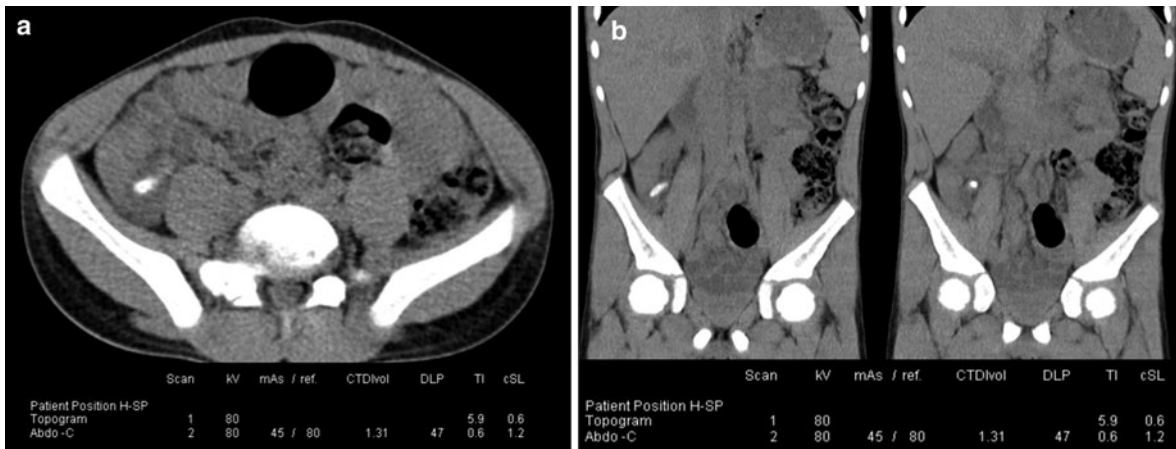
Unenhanced MDCT obtained at 80 kV in a 9-year-old boy weighing 34 kg after inconclusive ultrasound examination. Acute appendicitis is demonstrated by MDCT while CTDIvol is at 1.38 mGy only and DLP is lower than 50 mGy cm
